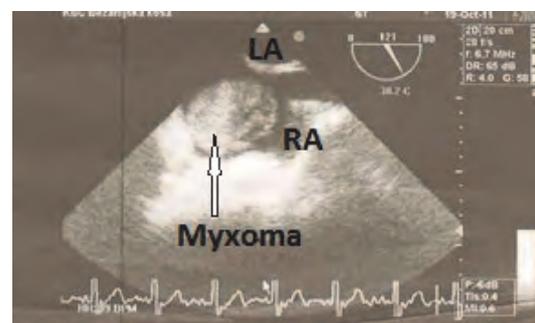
Transesophageal echocardiography revealed a large echo dense mass in the right atrium (LA = left atrium, RA = right atrium).
